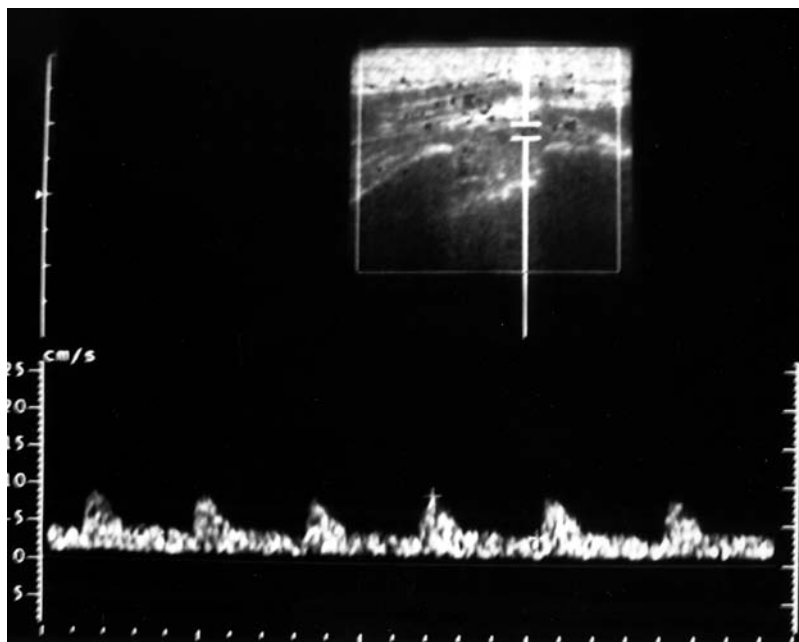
Low-resistance flow pattern compatible with acute inflammation obtained in spectral Doppler analysis of the right SI joint of one patient with active sacroiliitis.
